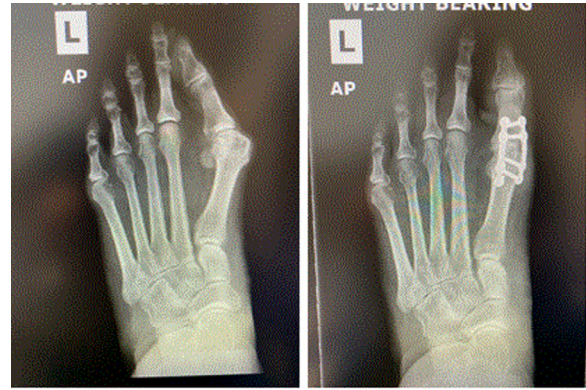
Preoperative and postoperative anteroposterior (AP) radiographs showing the triplanar first MTP fusion.
